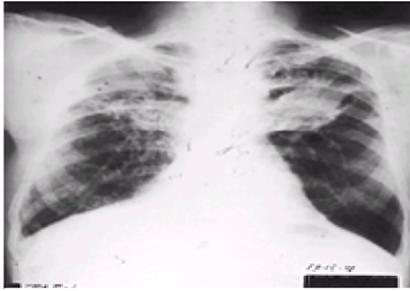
Chest radiograph of a worker with complicated silicosis. There is a conglomerate shadow in left middle-upper lung zone.
